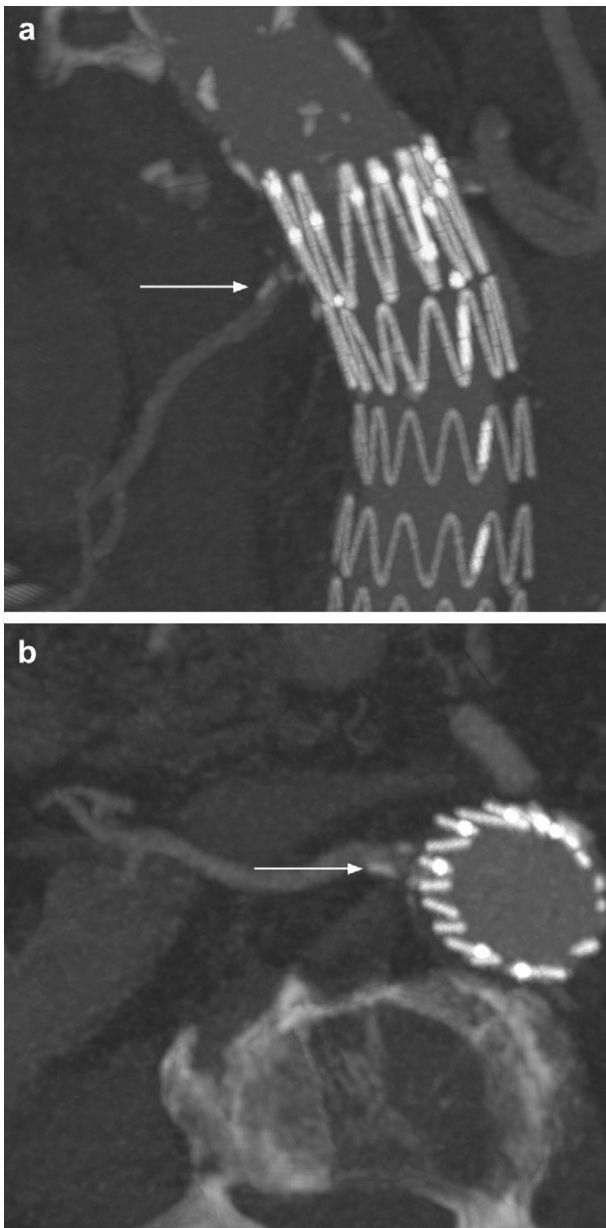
a) Coronal and b) axial computed tomography images of a Cook Zenith endograft showing the solder attaching the barbs to the top bare stent (arrow) in close proximity to the right renal artery. Image courtesy of Morten Vethus, Stavanger, Norway.
